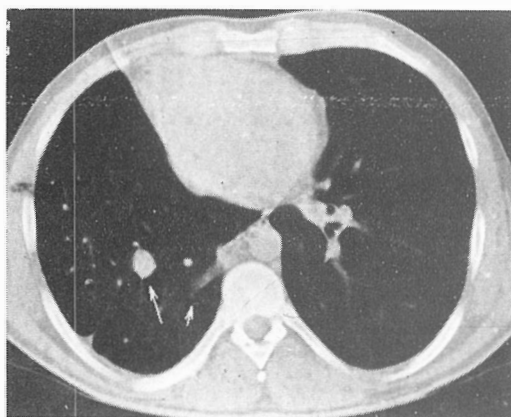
CT scan showing an anomalous vein (long arrow) and an anomalous vein draining into v. azygos (short arrow).
